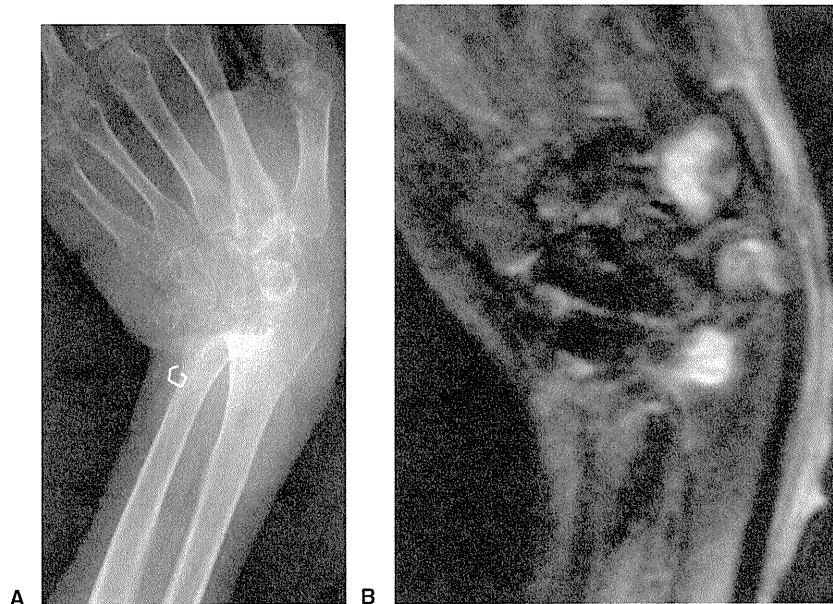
Images of the left hand. A X-ray of the wrist joint taken at our hospital shows destructive change in the radiocarpal, ulnocarpal, and midcarpal joints. B Magnetic resonance image of the left hand taken at our hospital shows inflammation in the radiocarpal joint and in the trapezium with high intensity in the T2-weighted image (with fat suppression).
